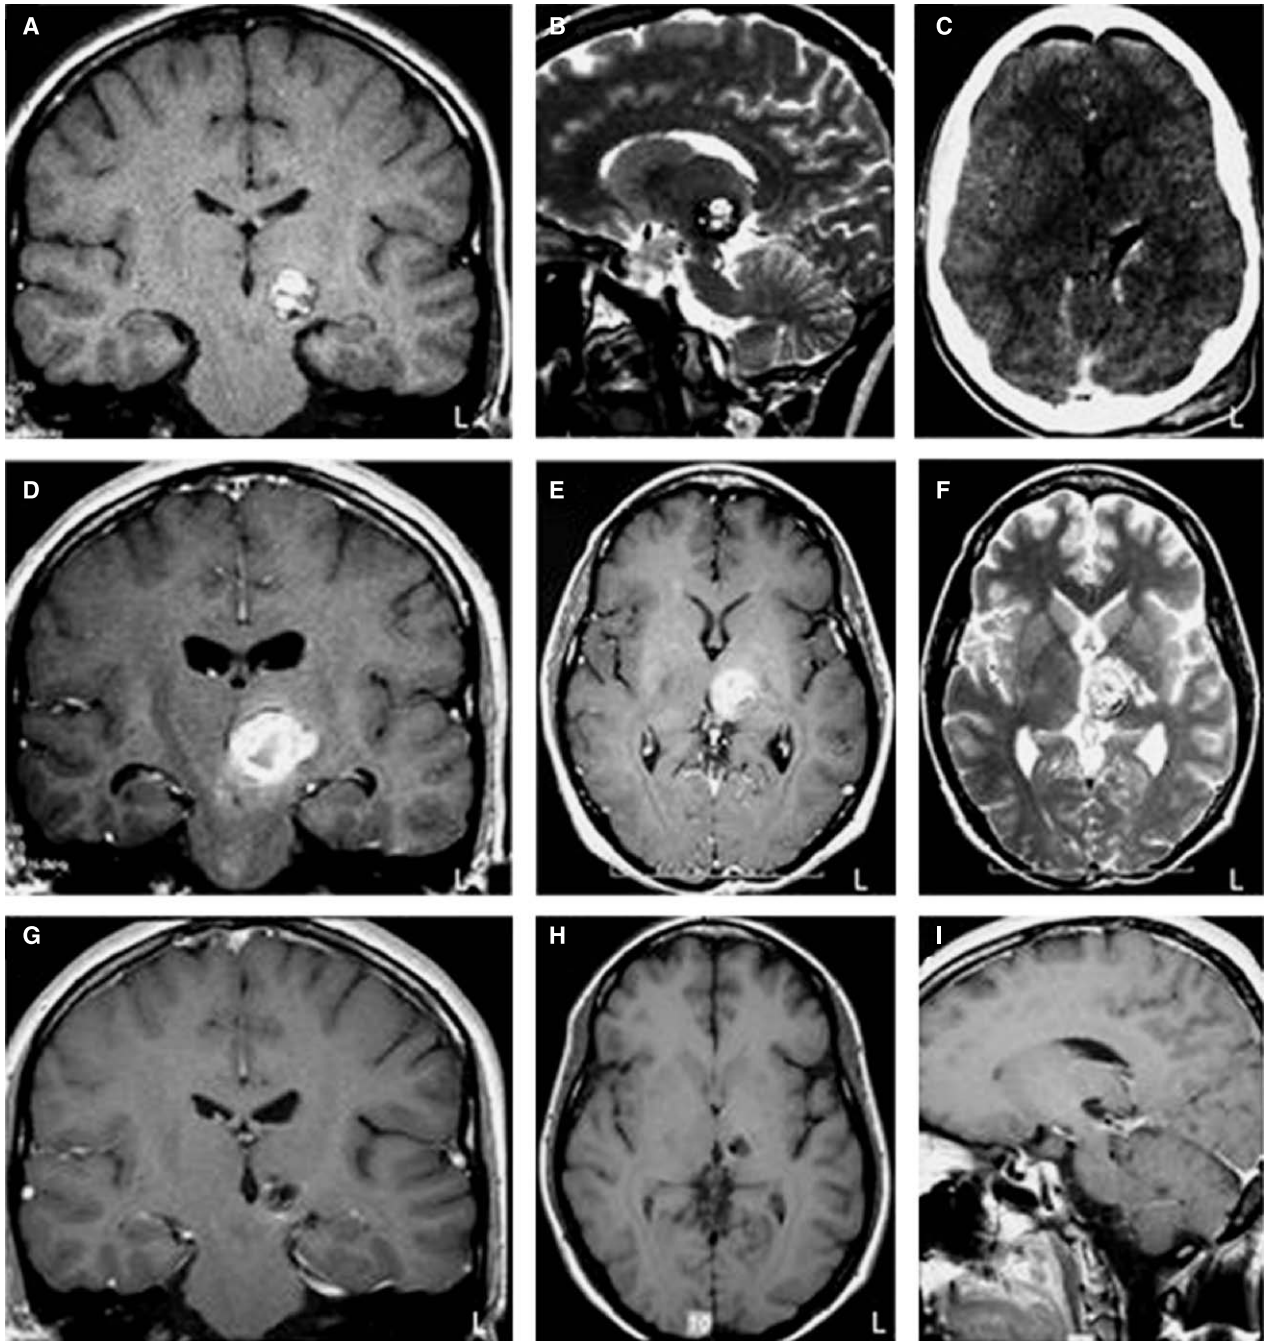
Case 1* Coronal T1-weighted (A) and sagittal T2-weighted (B) MR images of a 20-year-old woman, who presented with right sensorimotor disturbance and double vision, showing a cavernous malformation of 2 cm in size in the left thalamus (pulvinar). The CT scan obtained 2 days after surgery (C) showing the total removal of the thalamic CA. The follow-up MRI showing the recurrence of thalamic CA seven years later (D–F: T1, T1 and T2 weighted images). The postoperative MRIs showing the total removal of the thalamic CA (G–I: coronal, axial, and sagittal T1WIs)
